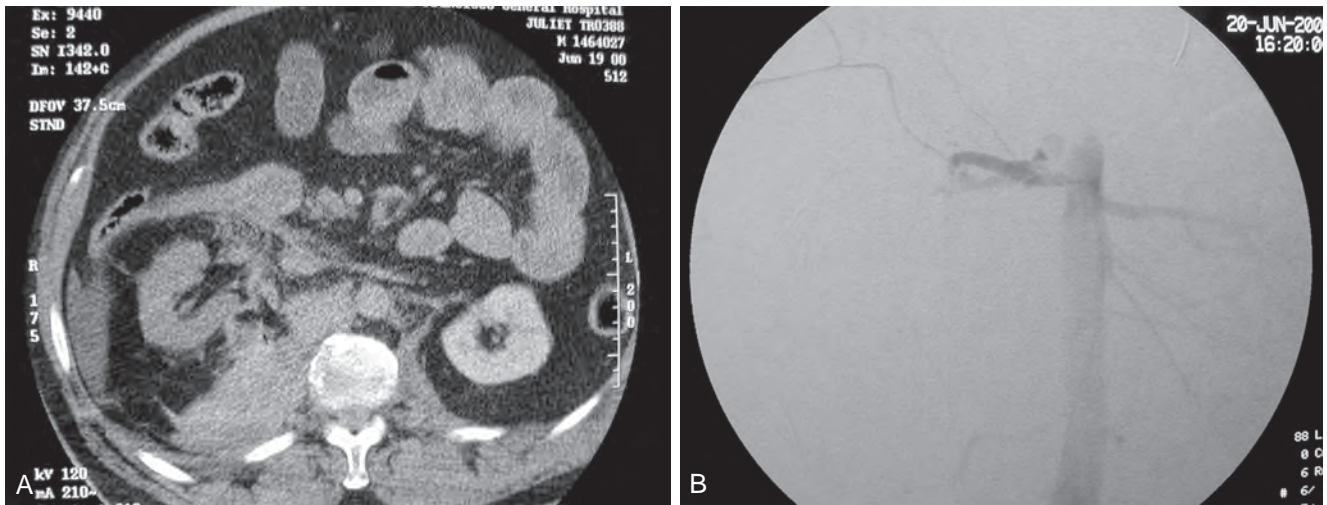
A, Computed tomography showing right renal artery thrombosis after crush injury. Note poor contrast uptake in right kidney compared to left and diffuse soft tissue injury medial to right kidney in the area of the renal artery. B, Angiogram showing right renal artery thrombosis after crush injury.
